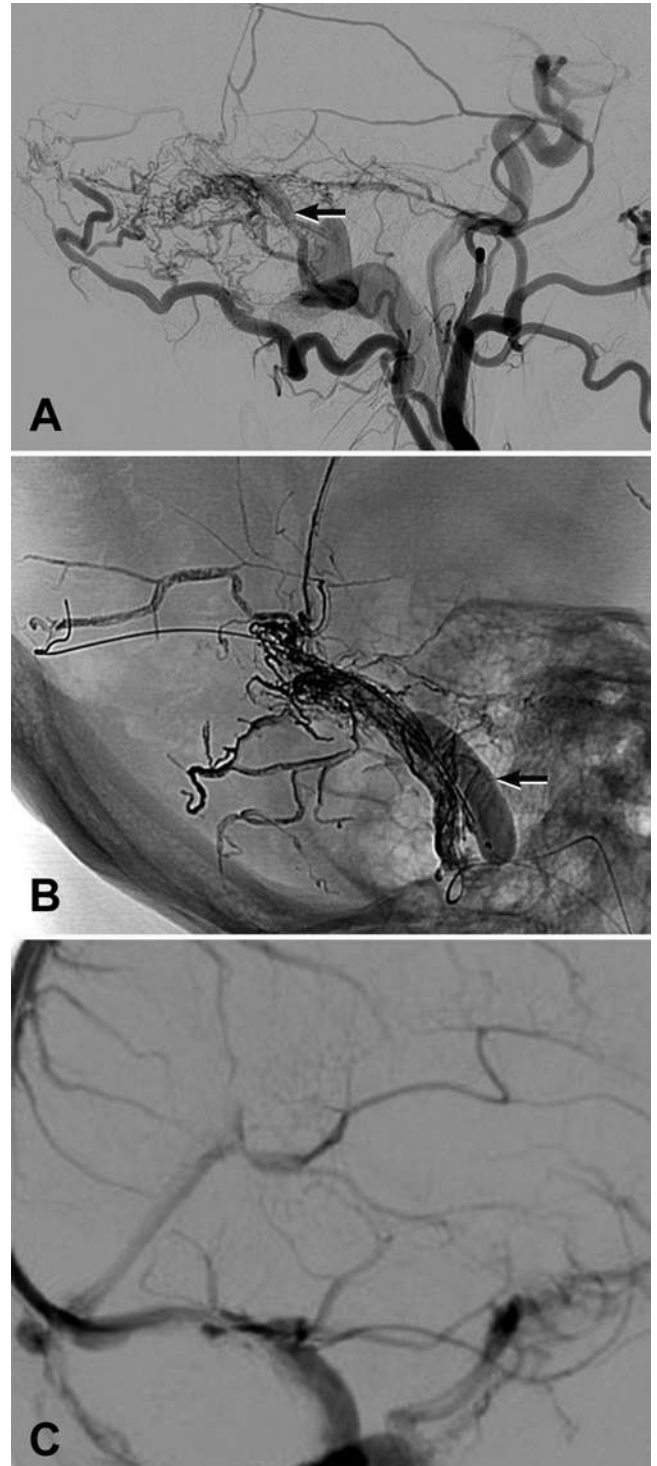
Lateral view of an ECA injection demonstrating a sigmoid sinus dAVF supplied by MMA and occipital artery branches with a parallel venous pouch (arrow, A). Supply from the tentorial artery is also seen from reflux into the internal carotid artery. The parent sigmoid sinus is protected by inflation of a balloon in the sinus (arrow) during combined single-pedicle MMA simultaneous transarterial and transvenous Onyx embolization (B: lateral skull radiograph demonstrating a casted dAVF vein). Sigmoid sinus outflow is preserved (C: lateral view of venous phase of internal carotid artery angiogram).
